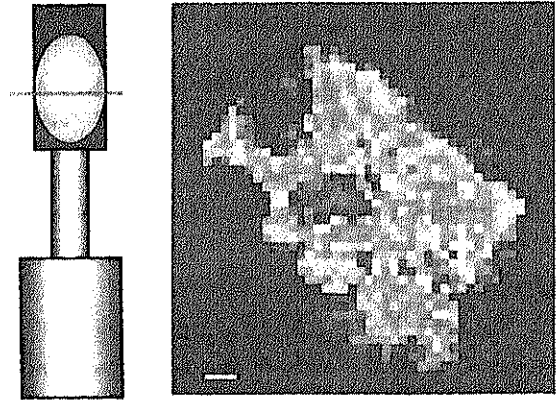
Fluorescent x-ray CT image of normal thyroid gland obtained at 0.05mm spatial resolution. Scale bar is 0.2mm.
